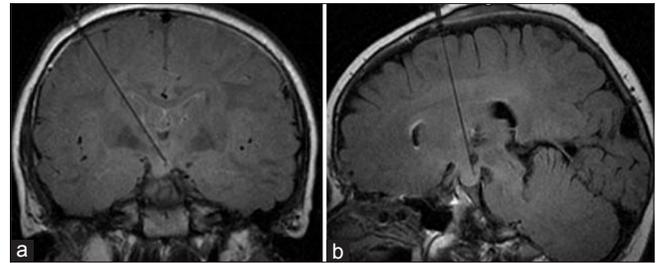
(a) Coronal and (b) oblique sagittal views of intraoperative magnetic resonance images show the laser probe trajectory during interstitial laser treatment of a hypothalamic hamartoma in a pediatric patient. Used with permission from Barrow Neurological Institute, Phoenix, Arizona
